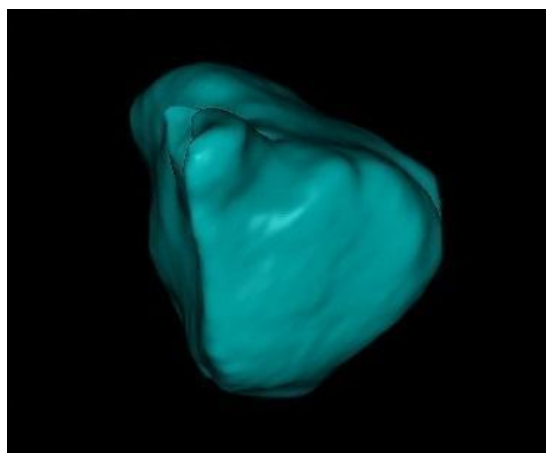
Three-dimensional volumetric image of a left maxillary sinus, obtained from a cone-beam computer tomography, using DDS-Pro™ software.
